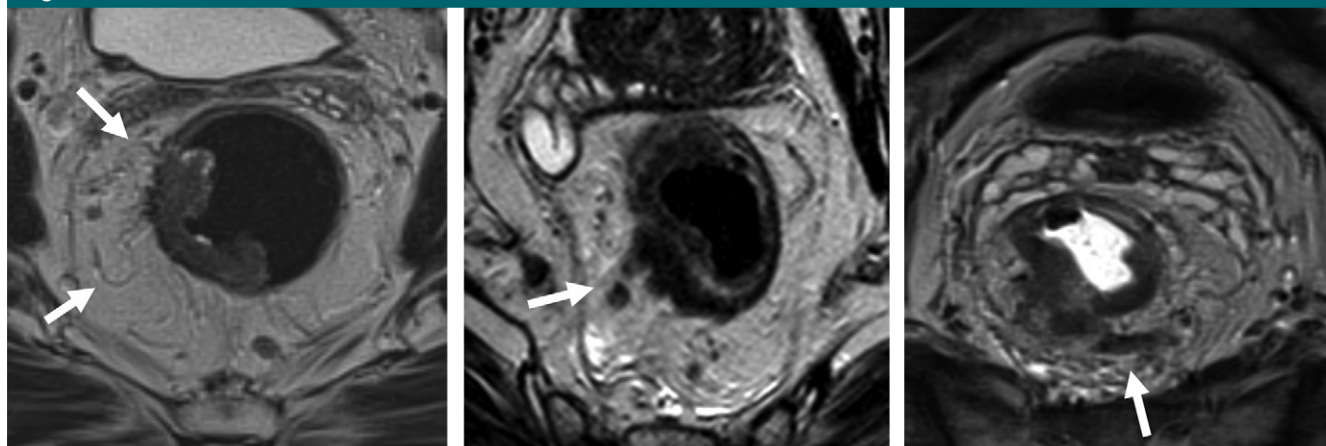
MR imaging EMVI panel. (a) Minimal extramural stranding, with some normal vessels adjacent to the tumor (arrows), but no tumor signal intensity within the vessel: no evidence of EMVI (see Fig 11, A). (b, c) Intermediate signal intensity within the vessels. The caliber of the vessel is enlarged (arrow), which is highly suspicious for EMVI (see Fig 11, B).
